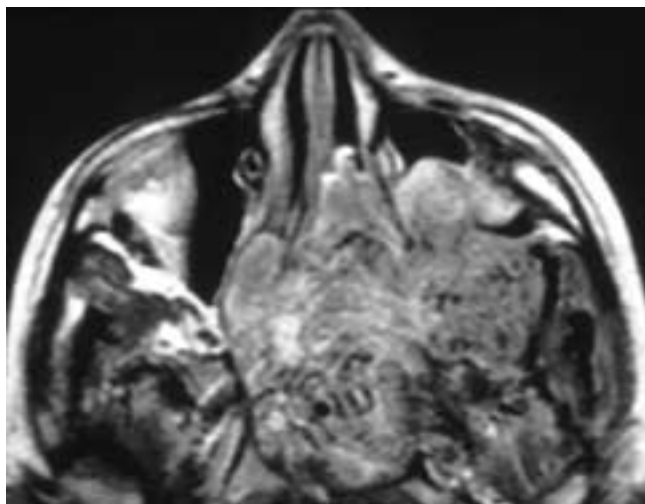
Axial T1-weighted MR image shows a large left nasopharyngeal and nasal fossa mass that extends into the left antrum. The mass also extends into the infratemporal fossa via the pterygopalatine fossa, which is widened and destroyed. The tumor further extends laterally to involve the left pterygoid muscles. There are multiple vascular-type flow voids within the mass. This patient had a large angiofibroma.
